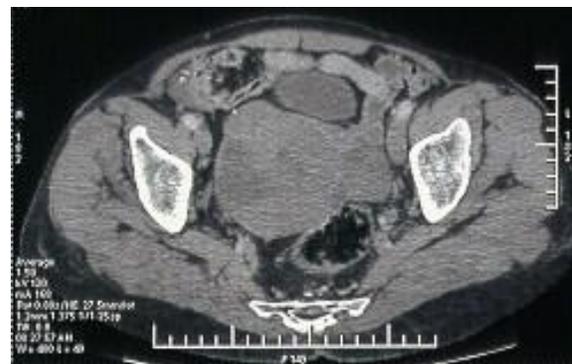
Axial pelvic computed tomography scan showing a bilateral adnexial mass with cystic components
